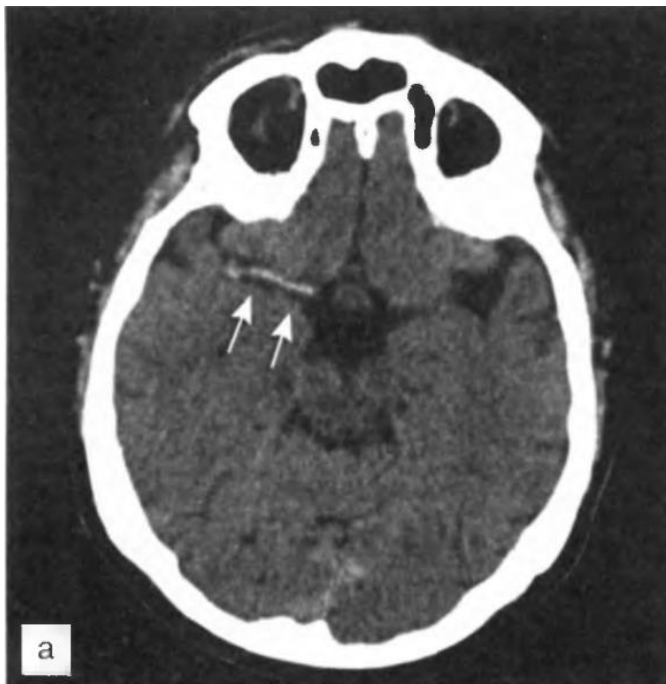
CT scan of the brain of a patient with ischemic stroke. Early signs of a stroke (a few hours after its development). Increased density of the right middle cerebral artery (sign of blood stasis; indicated by arrows).
